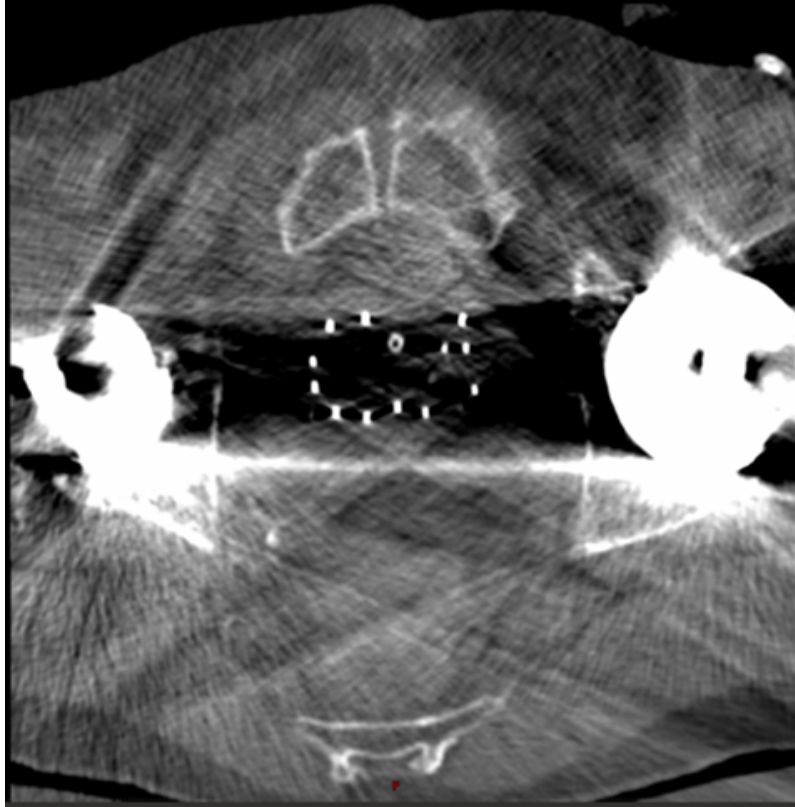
Example of metal artifacts caused by hip prosthesis in a CT scan for prostate brachytherapy.
